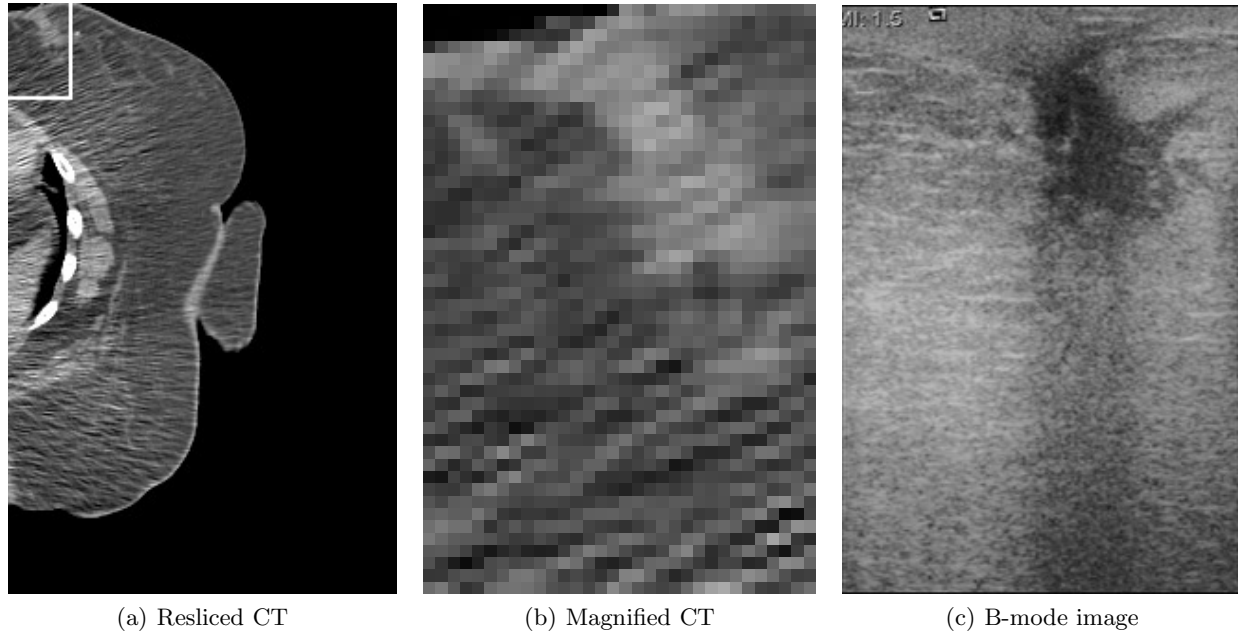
Comparison of CT and ultrasound cross sections. a) shows the cross-section of CT volume resliced based on B-mode image in c). b) depicts the white rectangle in a) and corresponds to c). The figures show superior resolution of ultrasound revealing structural details that are not visible in CT.
